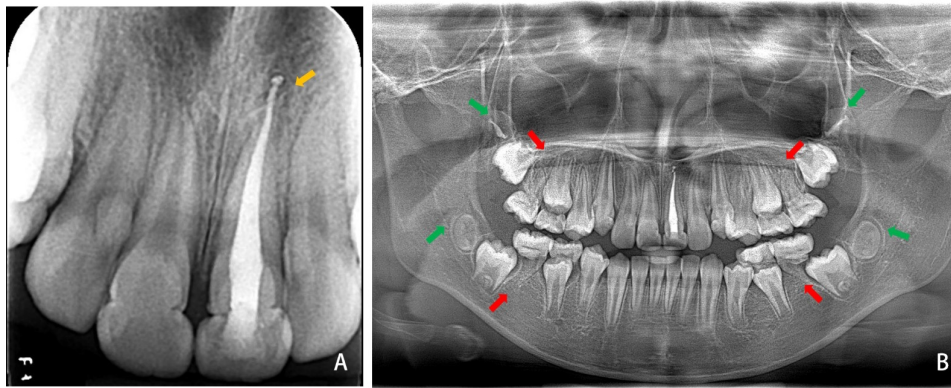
Radiographic findings at the 10-week follow-up. (A) Periapical radiograph. The yellow arrow showing no periapical radiolucency. (B) Panoramic radiograph. The red arrows showing no radiographic signs of periapical pathology with teeth 16, 26, 36, and 46, and the green arrows showing the third-molar tooth germs.
